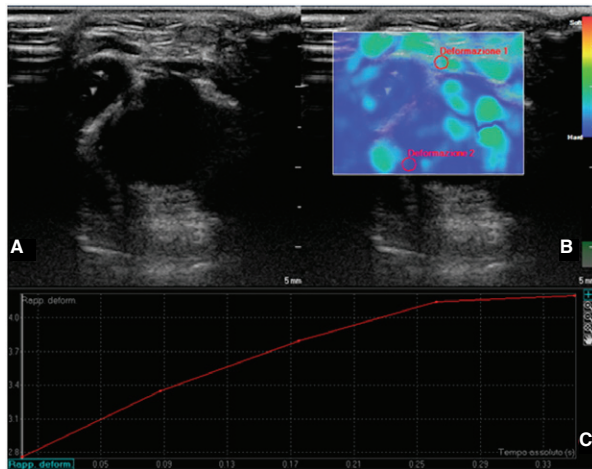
(A) Conventional Axial B-mode ultrasound scan and superimposed (B) sonoelastogram of the distal third of the Achilles tendon in a clubfoot showed a diffuse hyperechoic pattern highlighted in gray scale associated to a low elasticity of the structure, evaluated by sonoelastography mode. The elastography was evaluated positioning two circular ROIs, the diameter was about 3 mm each, respectively on the Achilles tendon and on the bone tissue. (C) The Strain index and the ratio was then calculated between the Achilles tendon and the bone tissue.
